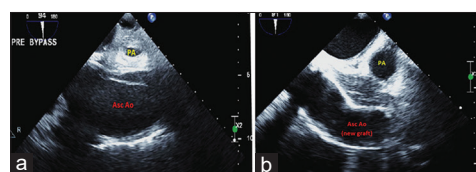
2D Transesophageal echo mid-esophageal long-axis view of the ascending aorta (Asc Ao). (a) Pre-cardiopulmonary bypass (CPB) a dissection flap is demonstrated on the posterior wall of the Asc Ao with an associated subadventitial hematoma and resultant compression of the right pulmonary artery (PA). (b) On post-CPB imaging, the Asc Ao is reconstructed with a resolution of the PA hematoma
